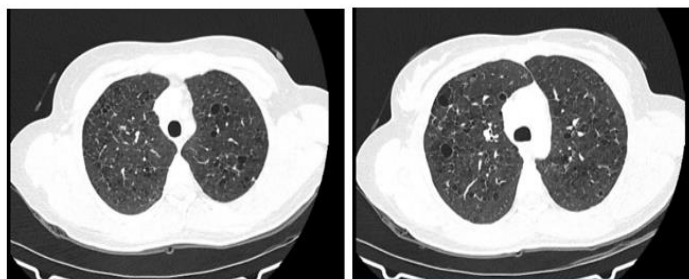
HRCT showing bilateral cysts of varying sizes in upper zone of lungs, some in close proximity to pleura.
